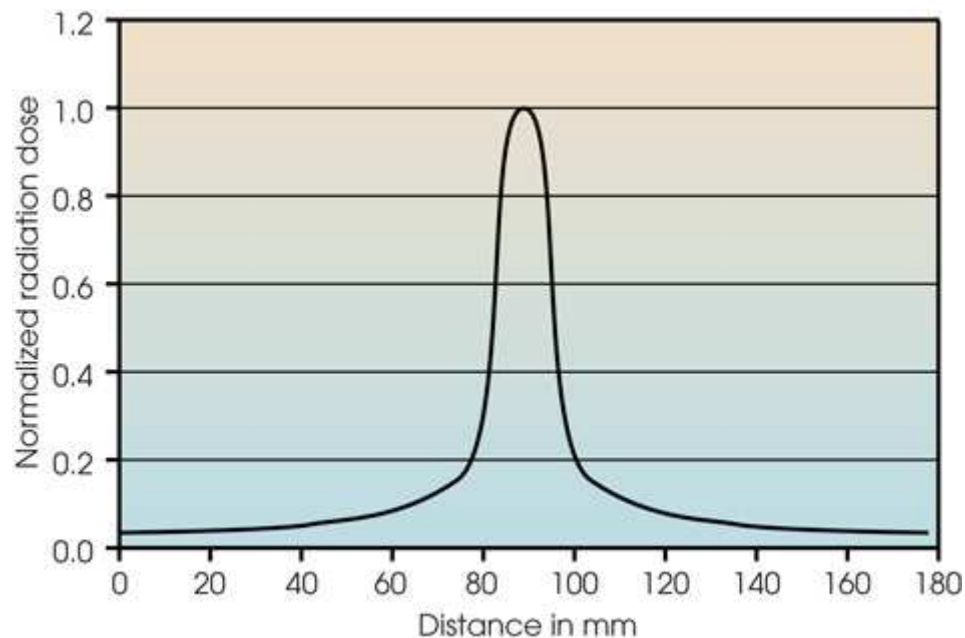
Single-slice CT dose profile.
